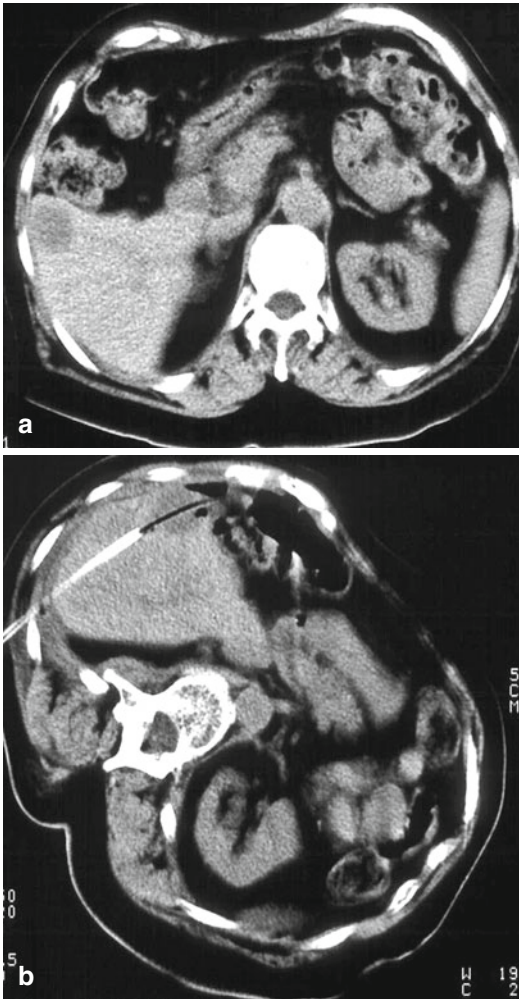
(a) The CT image is showing a metastasis at the anterior border of the liver. (b) The CT image is showing a positioned laser applicator
